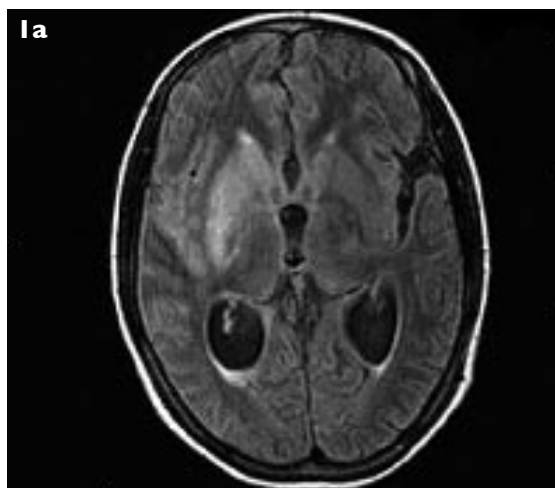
(a) Enhanced axial T1-W MR image shows an infarct in the right middle cerebral artery territory. (b) Enhanced coronal T1-W MR image shows a suprasellar mass with enhancing exudates in the right sylvian fissure.
